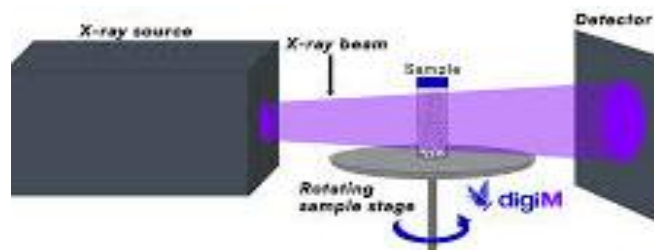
X ray microcomputed tomography
